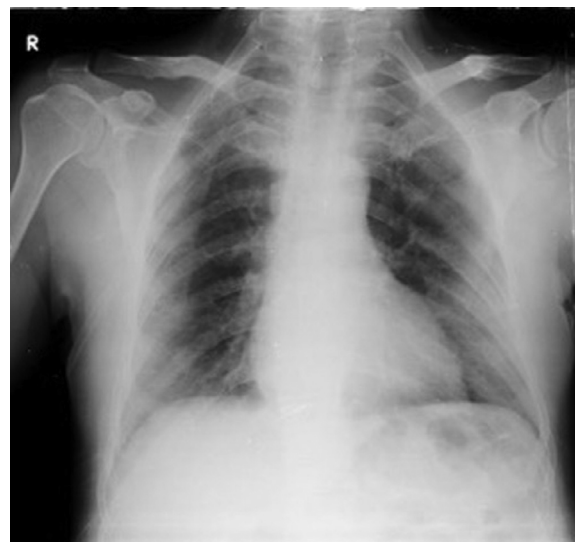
Chest radiograph of Patient One showing mild peripheral haziness, mainly in the mid to lower lung zones.
